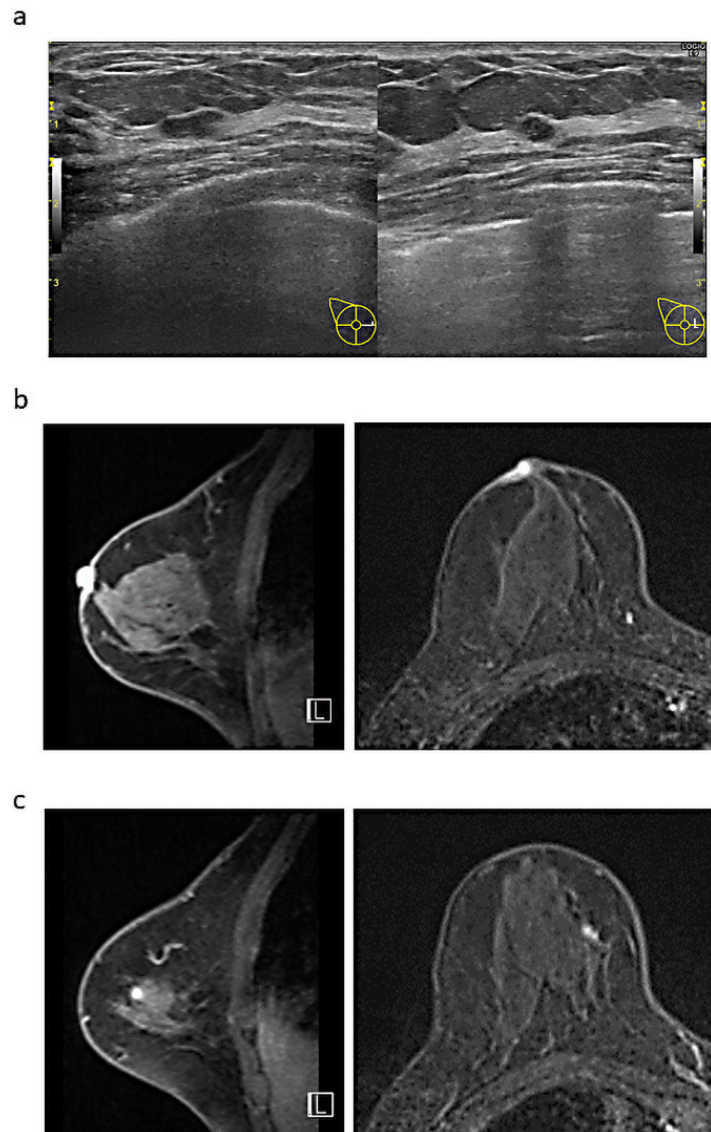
a Ultrasonography showed a hypoechoic solid mass in the inner right breast. b Magnetic resonance imaging showed relatively strong enhancement on the surface of the nipple and areola. c MRI showed an enhancing nodule within the inner breast.
